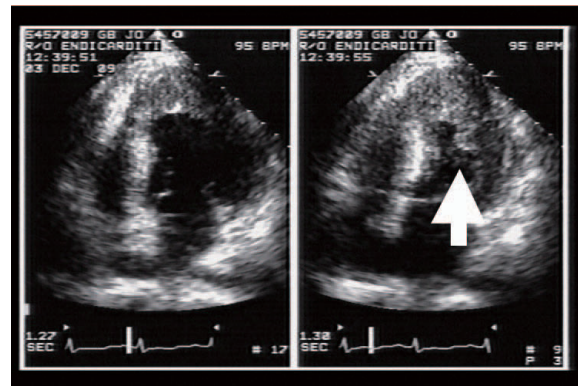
Echocardiography showed endomyocardial fibrosis in left ventricle (white arrows).
